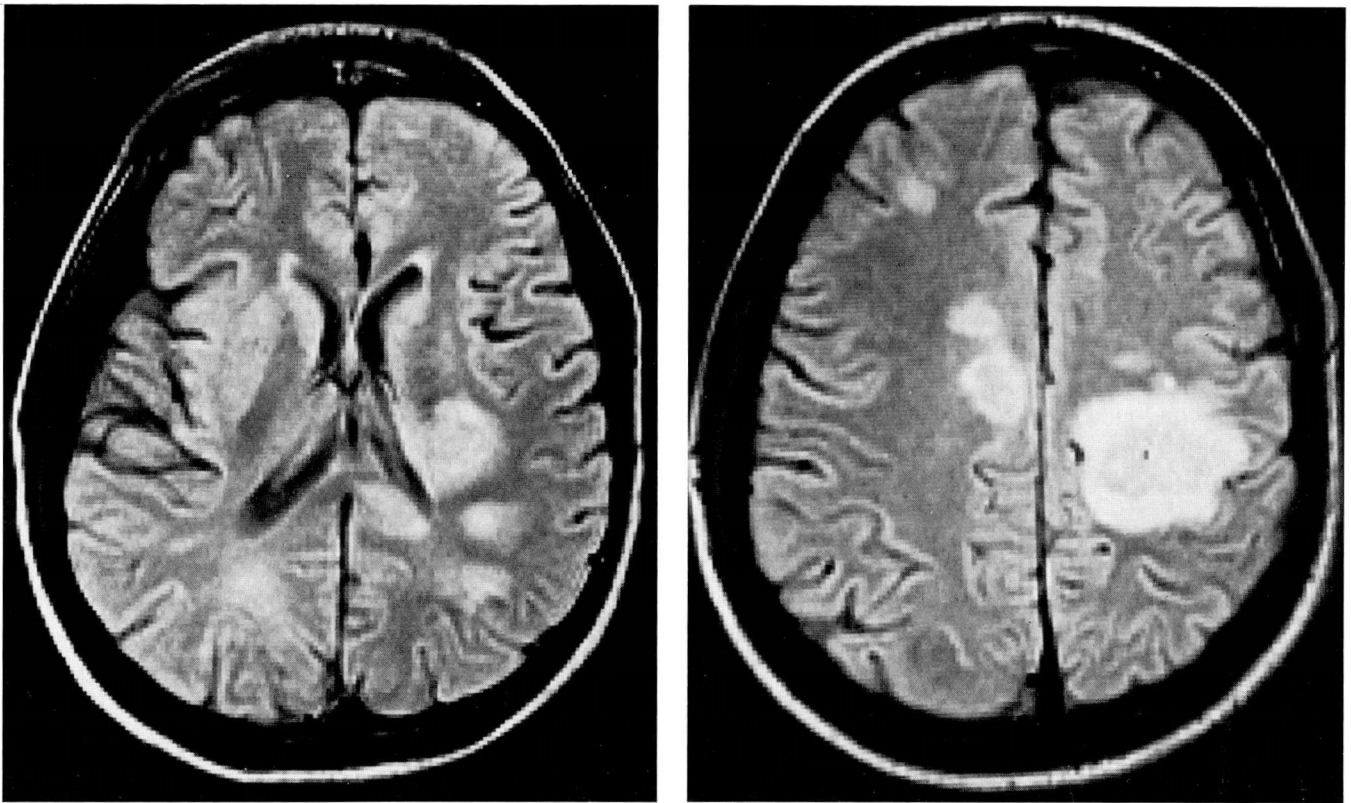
MR image shows multiple hemispheric lesions with surrounding edema. FIGURE 1B. MR image shows bilateral hemispheric lesions of the white matter.
